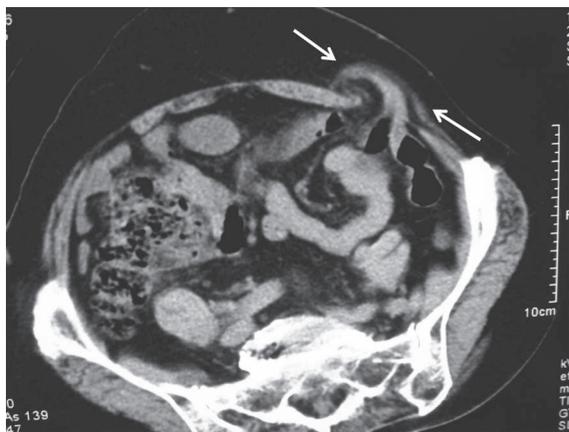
Preoperative computed tomogram. The small intestine can be seen herniating through the left lateral edge of the rectus abdominis muscle (arrow).
